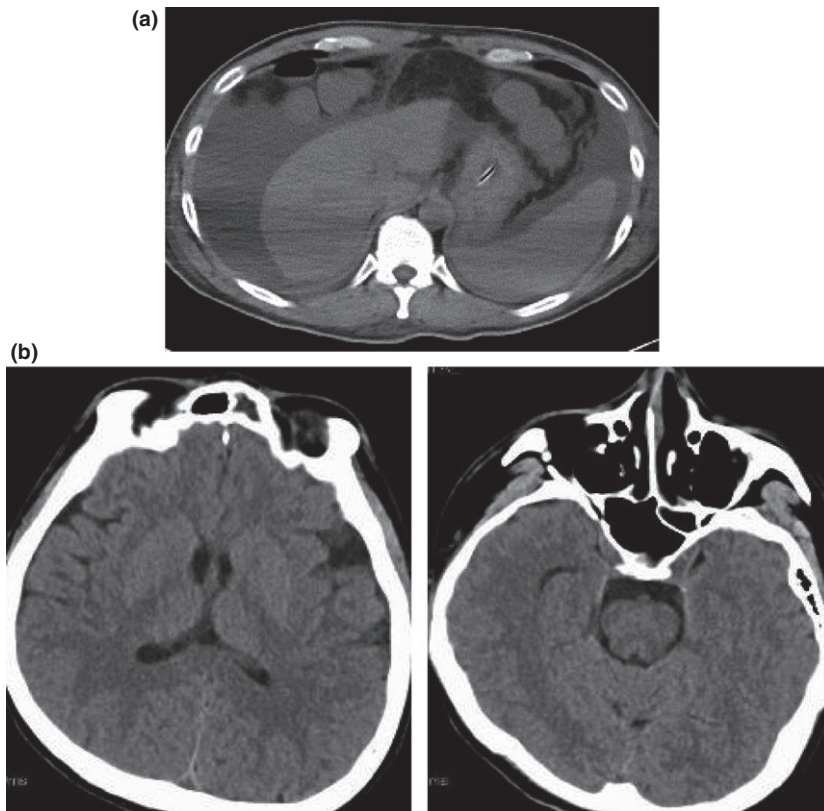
Abdominal enhanced computed tomography of the patient, (a) on admission and (b) 2 days after admission.
